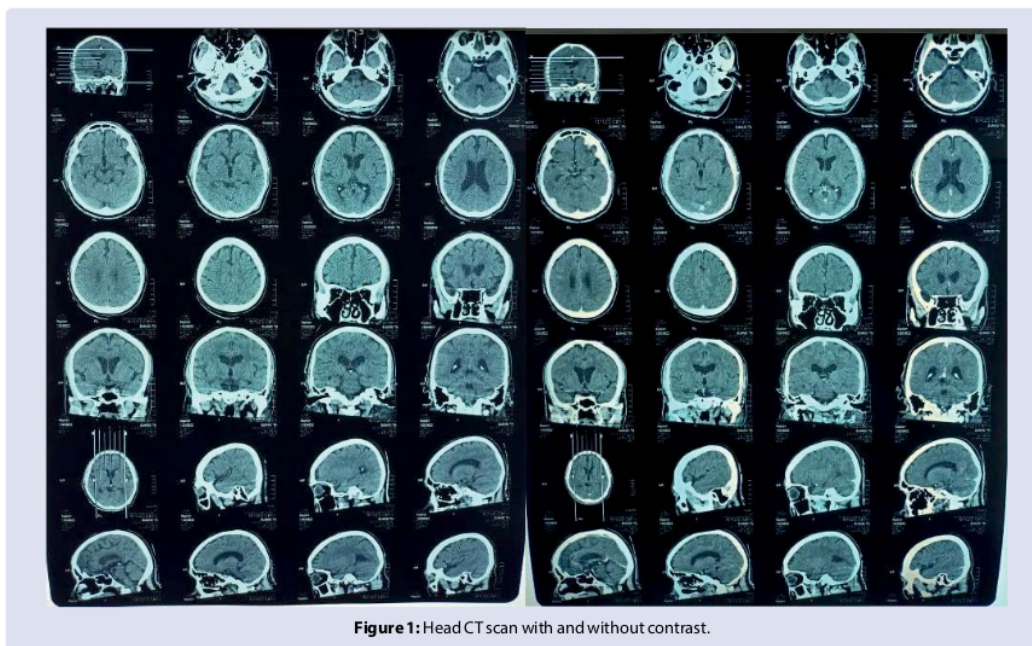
Head CT scan with and without contrast.
